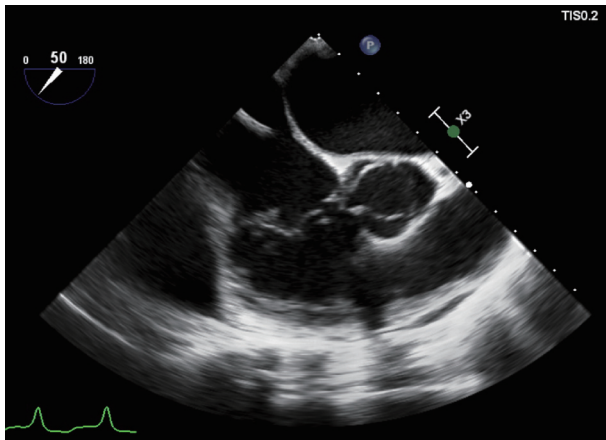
Transesophageal echocardiogram showing the vegetation adherent to the posterior leaflet of tricuspid valve. This exam was unremarkable for fibrin-sheath, masses or vegetations adherent to the electrocatheter.
